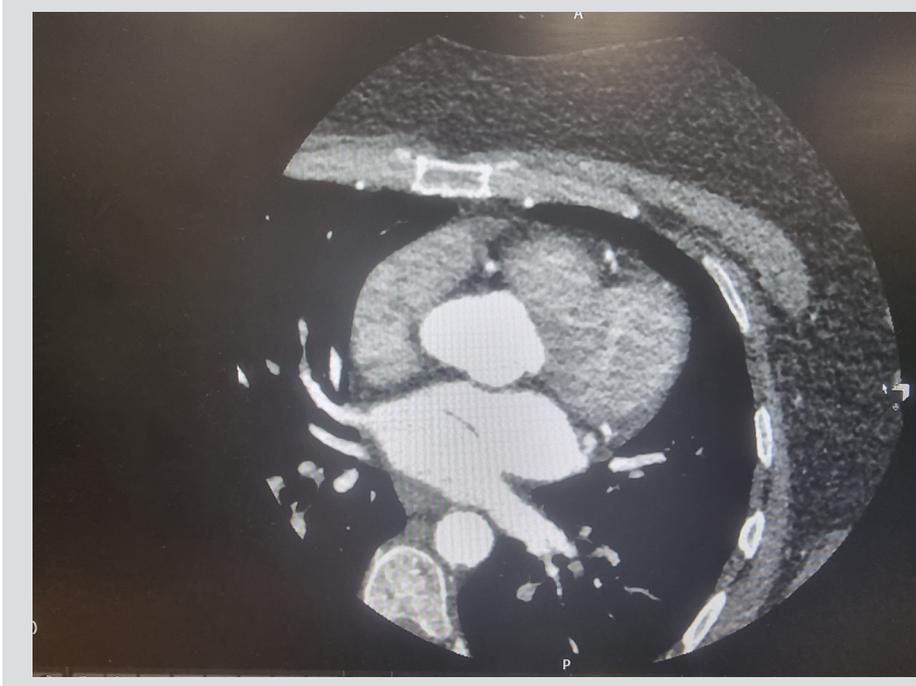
CT angiogram showing a non-obstructive membrane in the left atrium from the intra-atrial septum to the venous ostium with no thrombus
